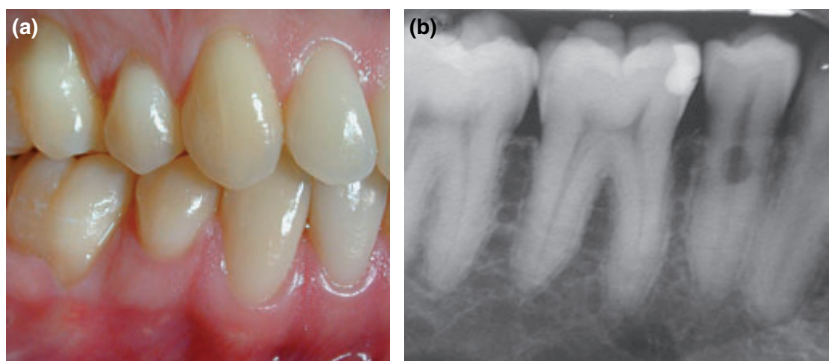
(a) Buccal view of the lower right quadrant; (b) radiograph of lower right quadrant revealing a cervical radiolucency on the lower right premolar.
